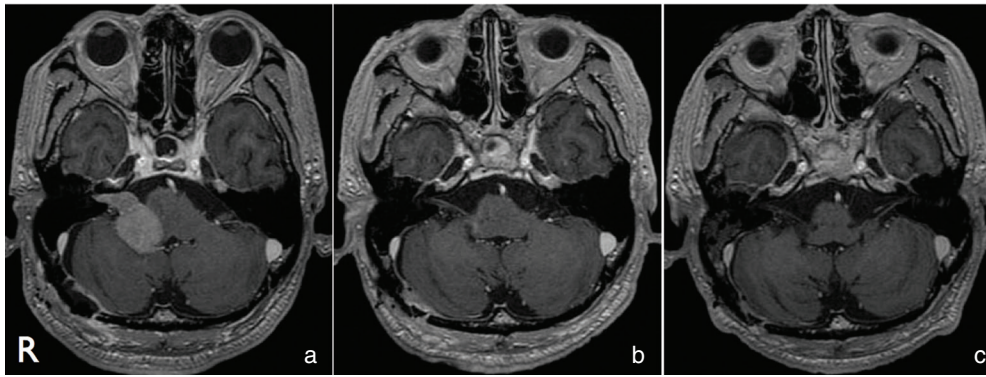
Serial gadolinium-enhanced T₁-weighted image. a: After two courses of chemotherapy, magnetic resonance imaging showed further enlargement of the cerebellopontine angle tumor. b: One month after radiotherapy, the tumor had remarkably decreased in size. c: Four months after radiotherapy, tumor had completely disappeared.
